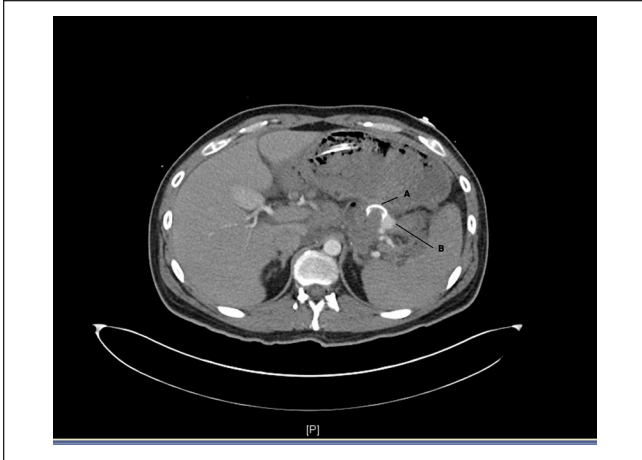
Computed tomography angiography for abdomen showing. (A) AXIOS stent connecting stomach and pseudocyst. (B) Bleeding from the posterior splenic artery.
